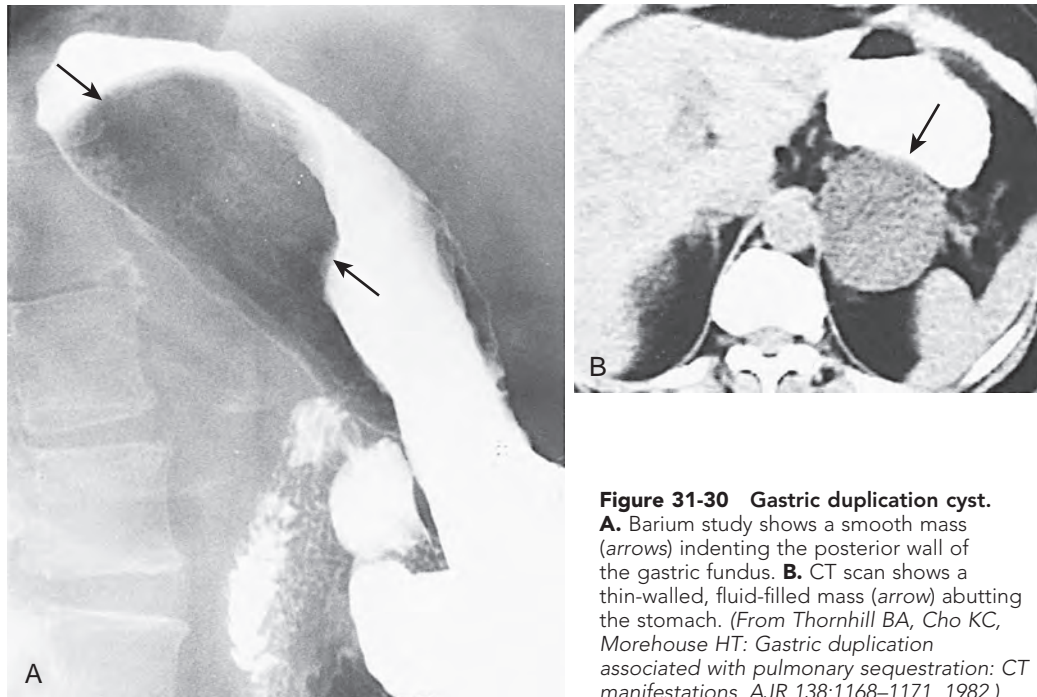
Gastric duplication cyst. A. Barium study shows a smooth mass (arrows) indenting the posterior wall of the gastric fundus. B. CT scan shows a thin-walled, fluid-filled mass (arrow) abutting the stomach. (From Thornhill BA, Cho KC, Morehouse HT: Gastric duplication associated with pulmonary sequestration: CT manifestations. *AJR* 138:1168–1171, 1982.)
